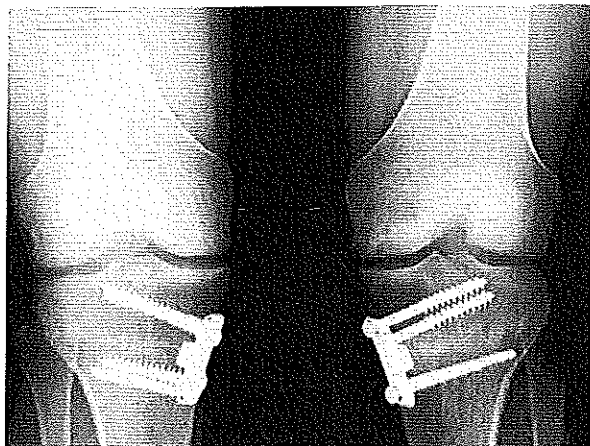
One year postoperative radiographs in an 18-year-old patient with bilateral OCD lesions of the medial femoral condyles treated with fresh OC allograft transplantation and simultaneously performed medial opening wedge osteotomies. The threshold to perform osteotomy to realign deformity to neutral or just beyond neutral is considerably reduced because of our understanding of the necessity to unload the cartilage restoration procedure.
